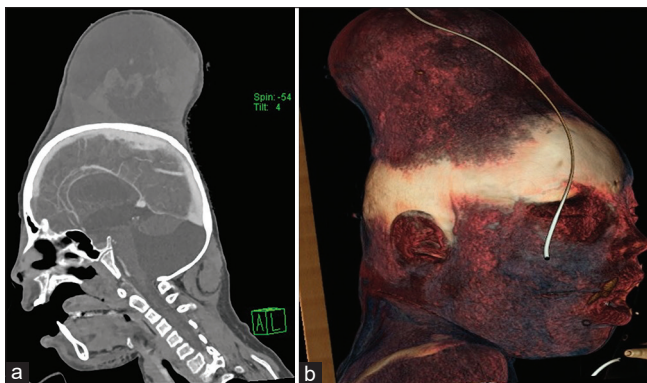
CT obtained after compressive bandage. (a) Sagittal view and (b) 3D reconstruction of emergency CT.
